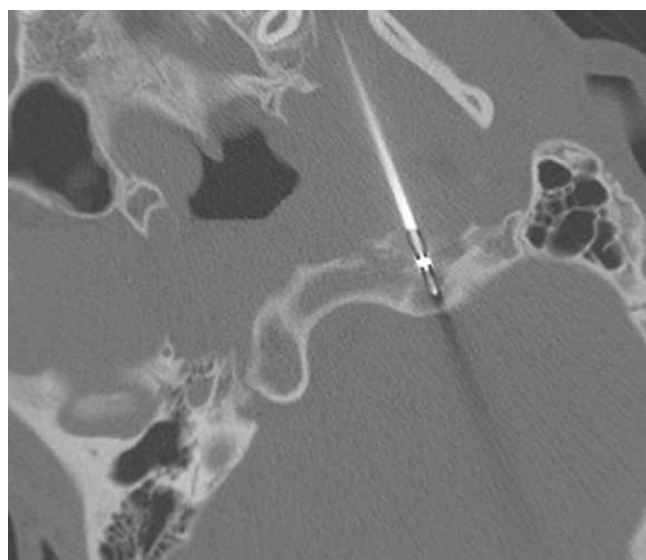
Axial CT obtained during second treatment, showing infrazygomatic approach with RFA wand deployed coaxially through a 14-gauge needle into the CB. Note that the more medial cystic ABC-like area in the clivus is healing and ossifying because of the first doxycycline treatment.
